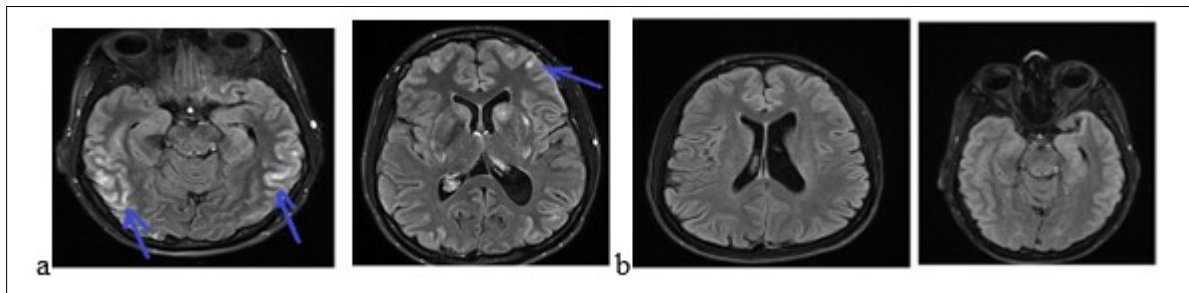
The brain MRI with flair sequences showing bi-temporal and frontal hyper signals (a) and a complete decrease of lesions after treatment (b).
